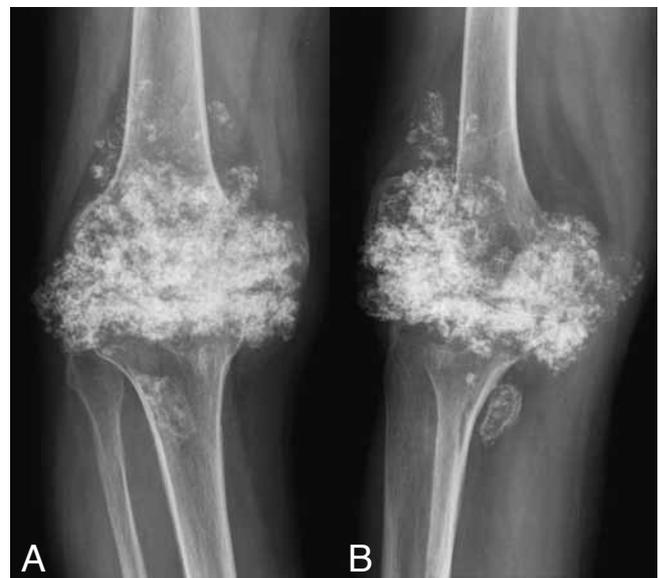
A. Anteroposterior and B. lateral projection of knee radiographs show extensive intra-articular synovial chondromatosis.
